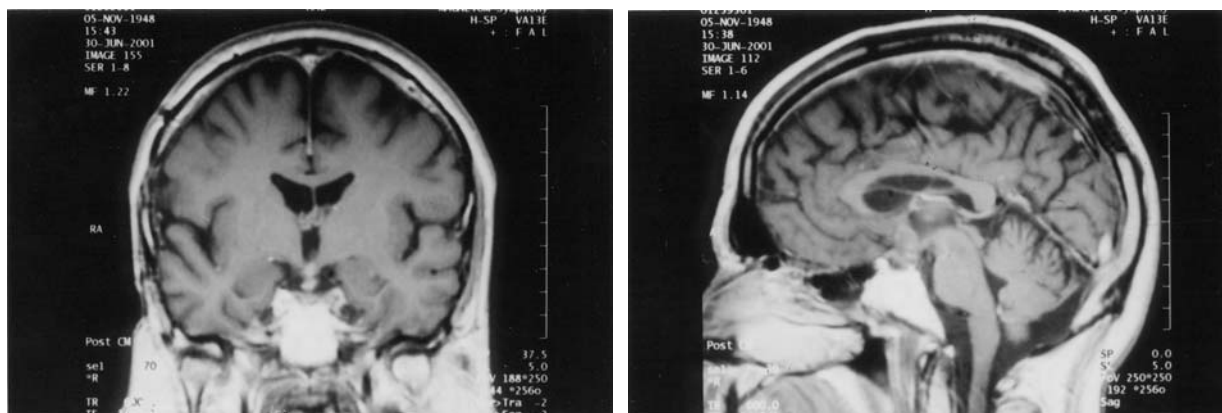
Follow-up T1-weighted magnetic resonance image with contrast administration (six years after operation) displaying a small remnant of the tumour in the floor of the third ventricle with a patent chiasmatic cistern and intact pituitary gland. *Left*: coronal section; *Right*: sagittal section. (TR 600 msec, TE 20 msec)
